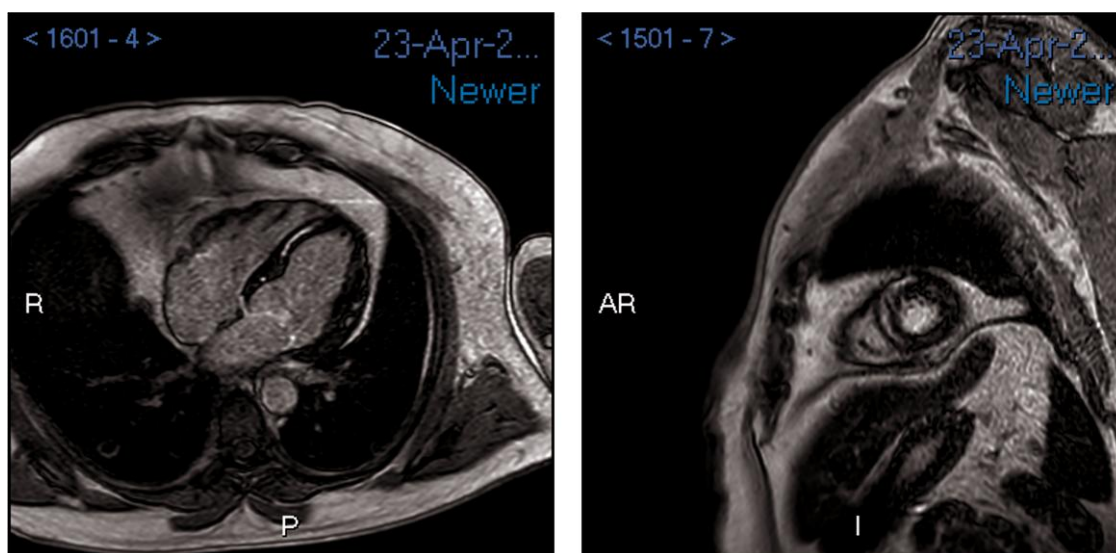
Repeat magnetic resonance imaging (MRI) 3 months later. Four-chamber and short-axis T1-weighted inversion recovery images acquired 10 min following the administration of gadolinium-based contrast agent showing significant interval improvement of the mid-wall myocardial enhancement.
